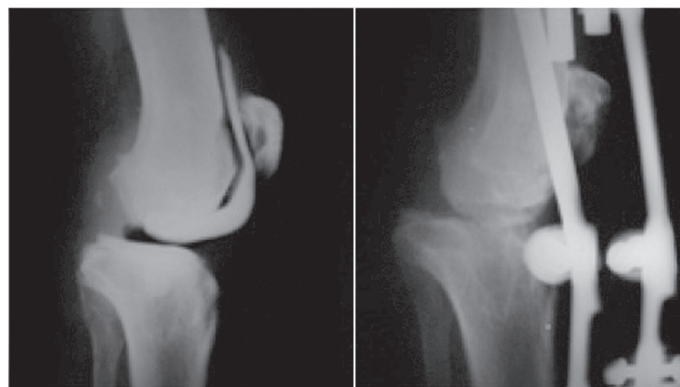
Plane X-ray images: spacer with antibiotics and late stage of arthrodesis
